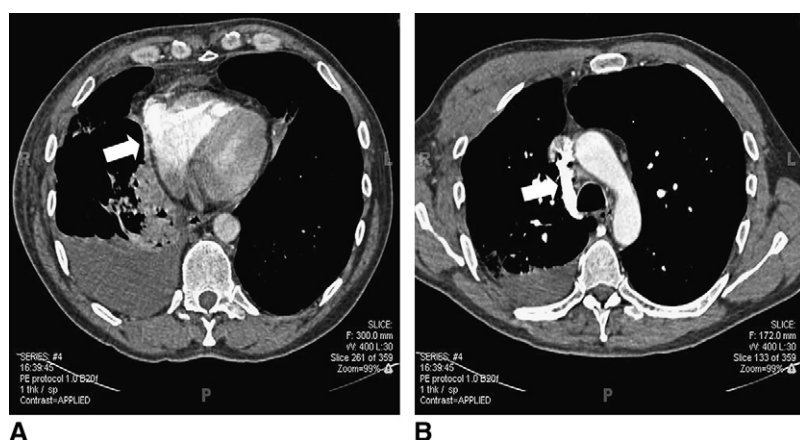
A, Flattened appearance of the right atrium on a CT scan obtained 5 days later (*white arrow*). B, Retrograde filling of the azygos vein secondary to right atrial compression (*white arrow*).
